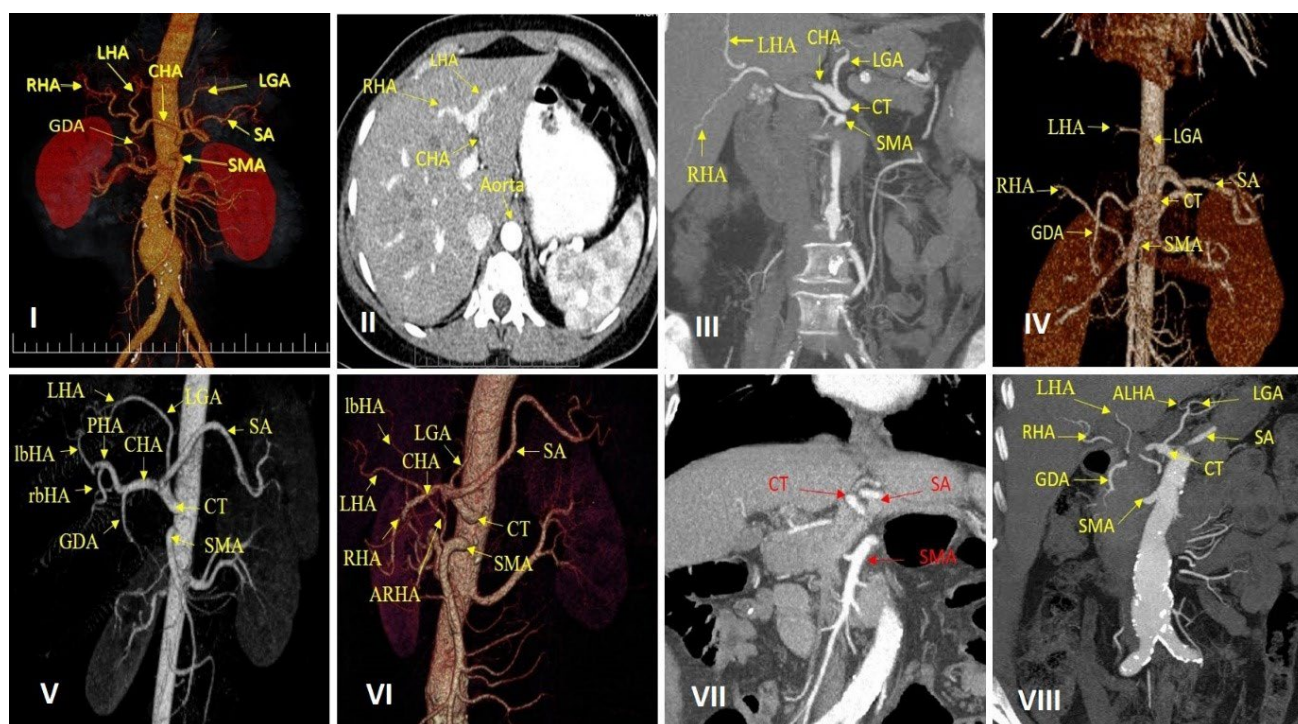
CT angiography images of hepatic artery variants in patients referred to Baqiyatallah hospital. CT: celiac trunk, LGA: left gastric artery, SA: splenic artery, CHA: common hepatic artery, GDA: gastroduodenal artery, PHA: proper hepatic artery, RHA: right hepatic artery, and LHA: left hepatic artery.
